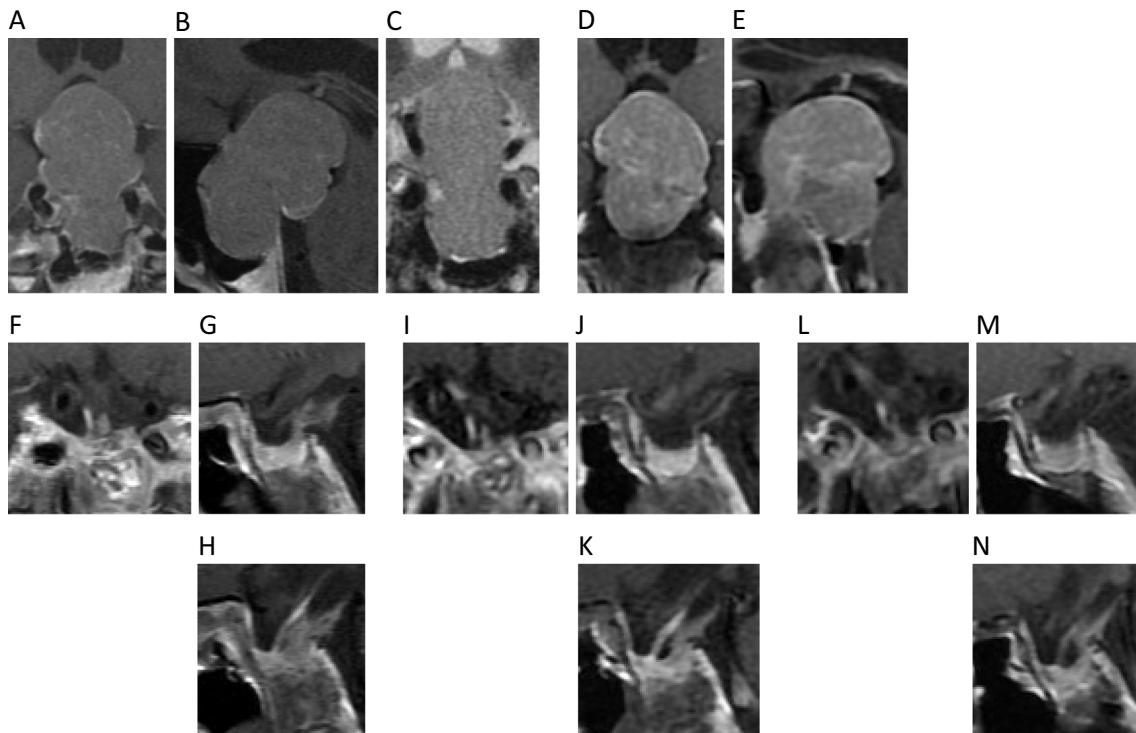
Pituitary MRI images at baseline [coronal T1 gadolinium-contrast enhancement (Gd-CE), A], sagittal T1 Gd-CE (B), T2 coronal (C), after partial resection of GH-secreting adenoma (coronal T1 Gd-CE: D, sagittal T1 Gd-CE: E), after 6 months of treatment with octreotide LAR (coronal T1 Gd-CE: F, sagittal T1 Gd-CE: G, H), after 24 months (coronal T1 Gd-CE: I, sagittal T1 Gd-CE: J, K) and after 30 months (coronal T1 Gd-CE: L, sagittal T1 Gd-CE: M, N).
